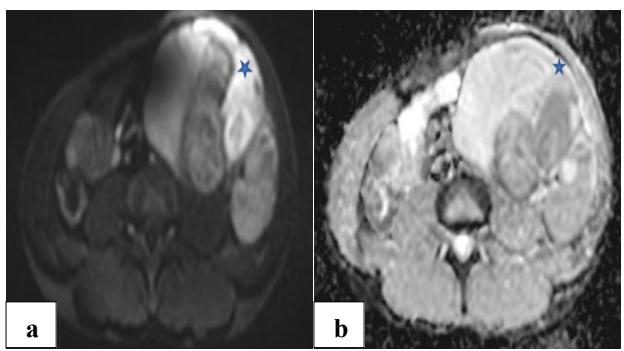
MR axial images (a) DWI, and (b) corresponding ADC map show a focal area (blue asterisk) within the mass appearing bright on DWI and dark on the ADC map.
